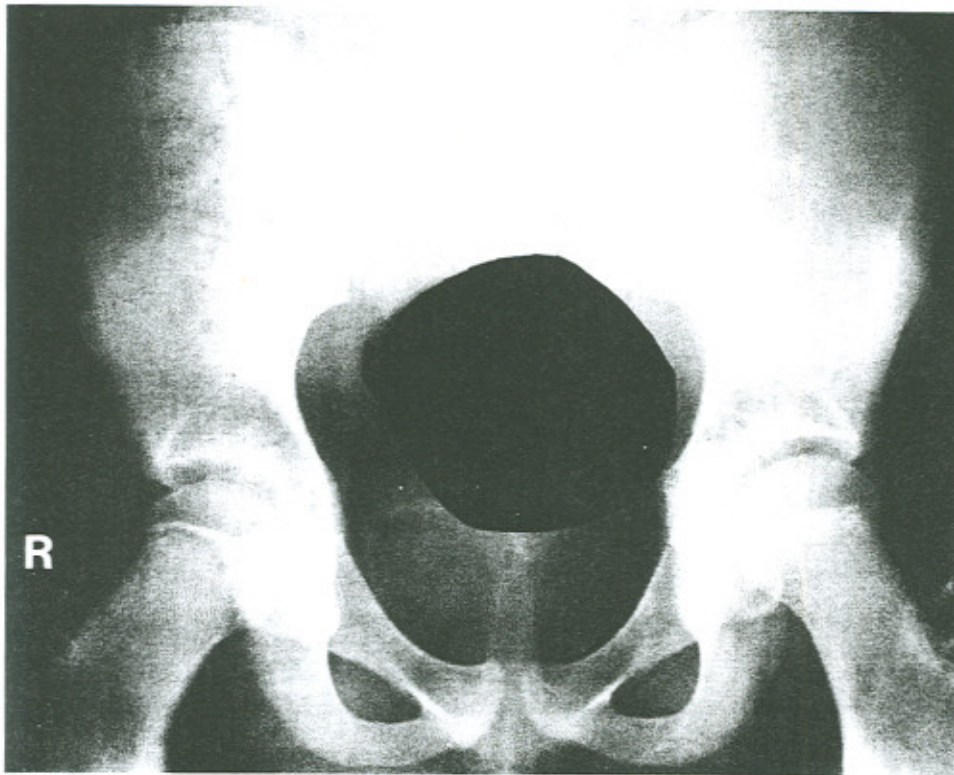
An anteroposterior radiograph of the pelvis of a 12-year-old female patient which was interpreted as normal.
